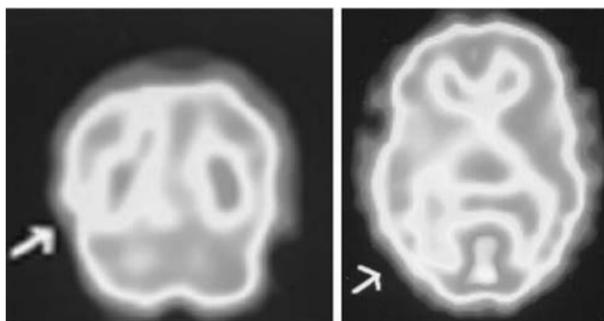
Coronal (left) and horizontal (right) single photon emission computed tomography (SPECT) images showing ^{99m}Tc-HMPAO distribution in a typical patient with pseudomigraine with pleocytosis 12 hours after an episode of headache accompanied by left sensory and motor symptoms. There is decreased tracer uptake posteriorly in the right hemisphere (arrows). A SPECT study performed on this patient 1 week later was normal. This 26-year-old man had had two previous episodes with aphasia and right sensory symptoms.
